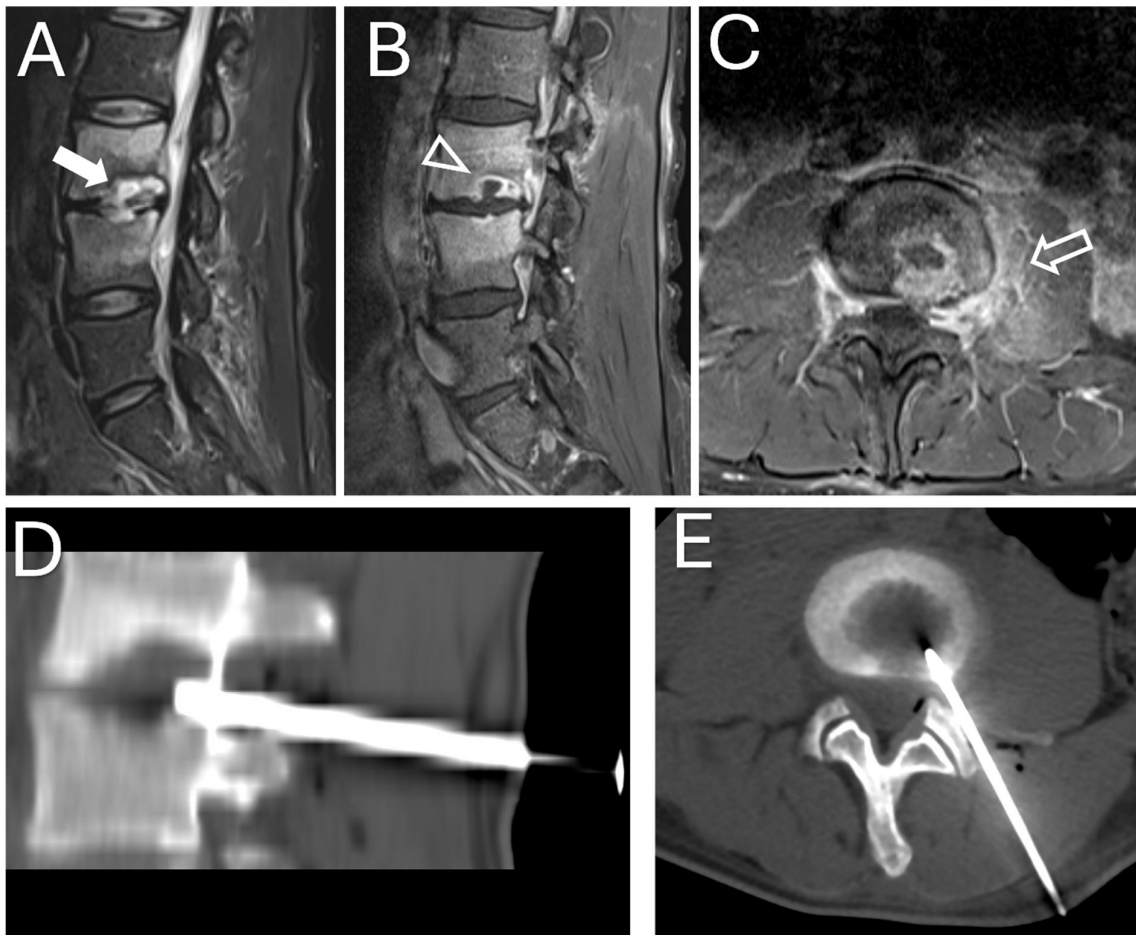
Sagittal STIR (A), sagittal post-contrast T1 (B), axial post-contrast T1 (C) MR sequences demonstrate imaging of L3-L4 vertebral osteomyelitis-discitis with disc-endplate irregularity, T2 hyperintensity centered within the disc (white arrow) extending in the adjacent vertebral bodies, peripheral enhancement of the irregular disc and endplates (outline arrowhead) with enhancement of the vertebral bodies and the paraspinal tissues (outline arrow). CT-guided biopsy with oblique sagittal (D) and axial (E) images show biopsy needle sampling of the disc-endplate margin.
